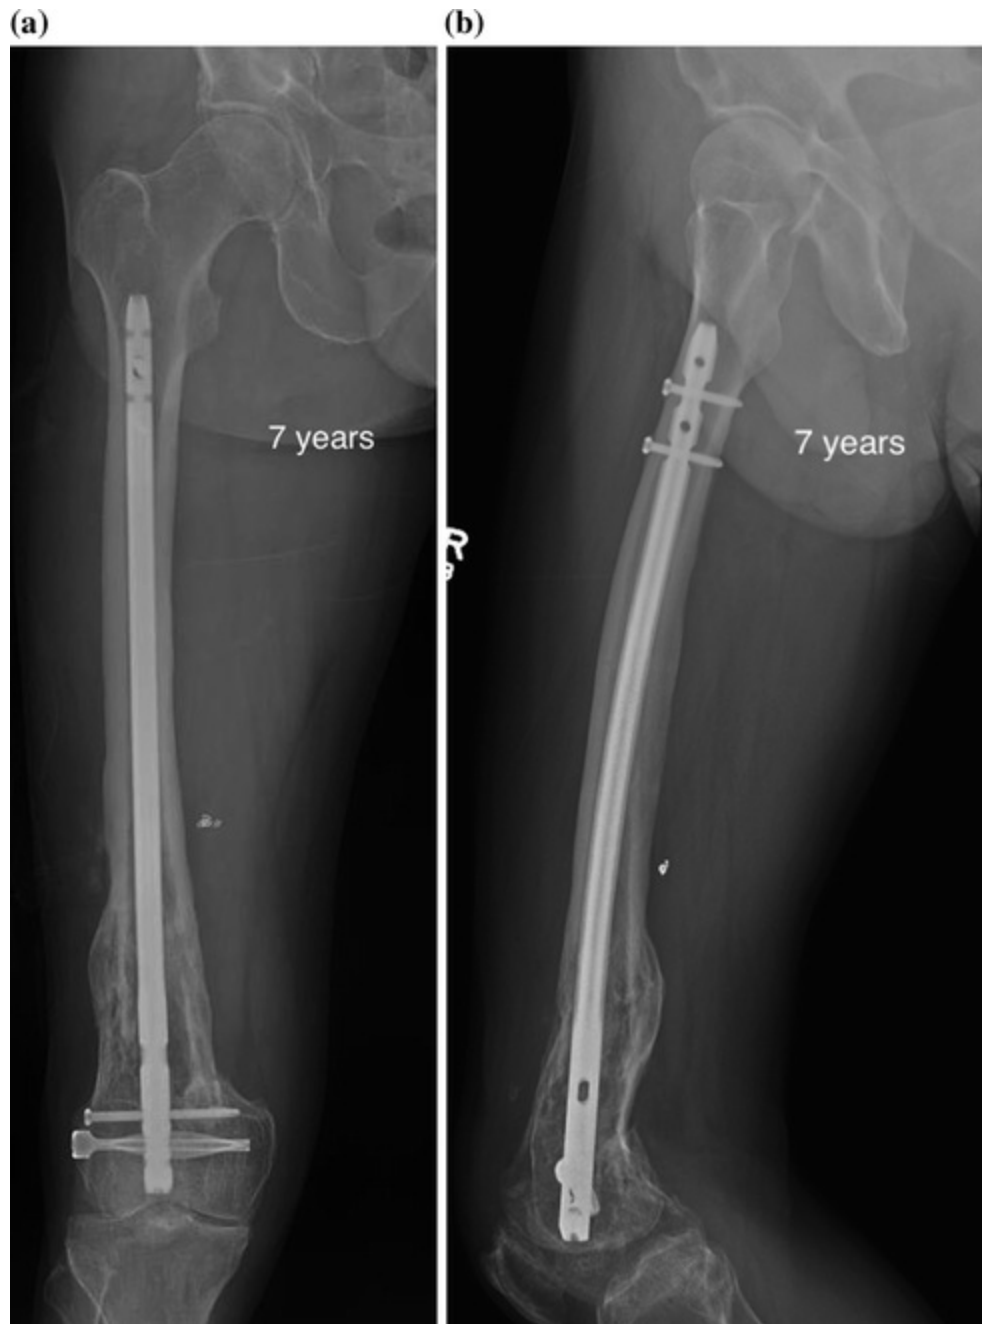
a Anteroposterior and b lateral radiographs of the right femur at 7 years showing well-healed femur with stable hardware
